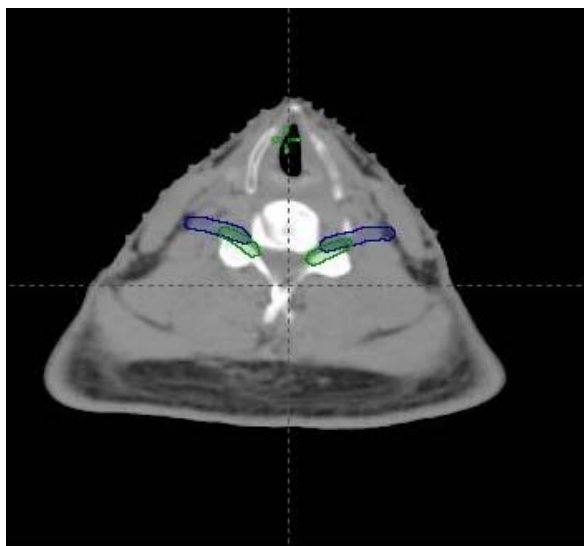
The overlapping of BP contours based on RTOG-eCA (blue) and MRI (green)
